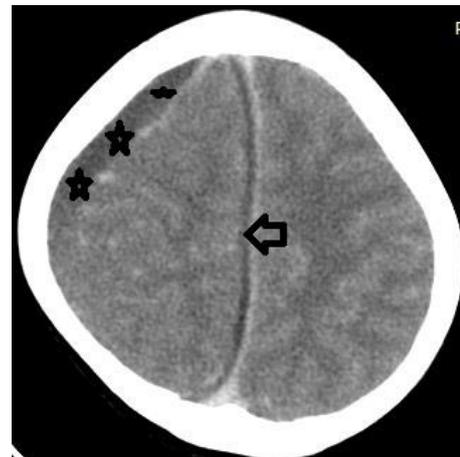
Contrast enhanced CT scan showing right convexity (stars) and parafalcine (arrow) subdural empyema.
